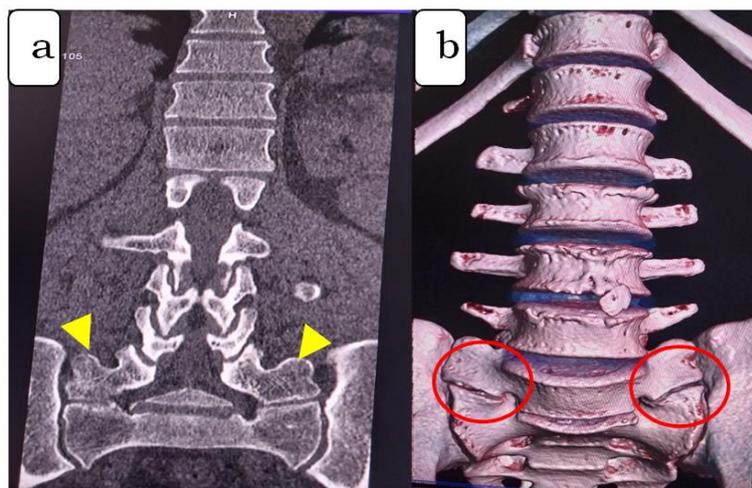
59-year-old H, lumbosacral spine CT, window coronal reconstruction Figure 3: 59-year-old H, lumbosacral spine CT, window coronal reconstruction bone in (A) and volume seen from the front in (B) showing a low back of S1 classified type IIB of Castellvi
